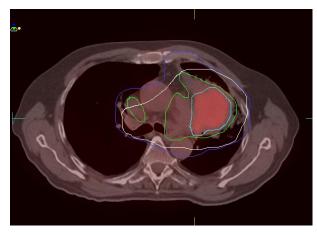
(A) GTV_{CT} and CTV_{CT} contoured by using CT scan only (without PET data). (B) $GTV_{PET/CT}$ and $CTV_{PET/CT}$ contoured by using combined PET and CT data. (c) Contoured CTV and GTV views taken from CT alone were registered with views taken from PET/CT.
